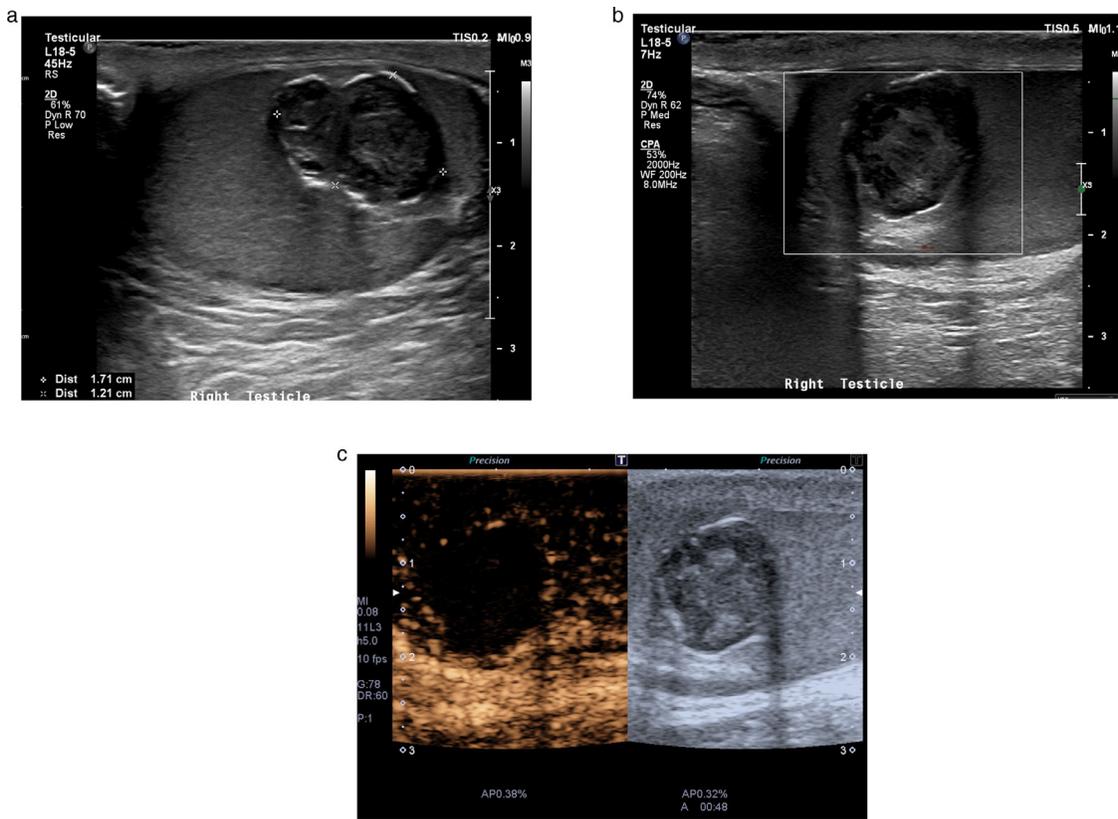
Epidermoid cyst. The mass exhibits an onion ring pattern on B-mode ultrasound (a) with no detectable internal vascularity on standard color Doppler (b) or contrast-enhanced ultrasound (c).
